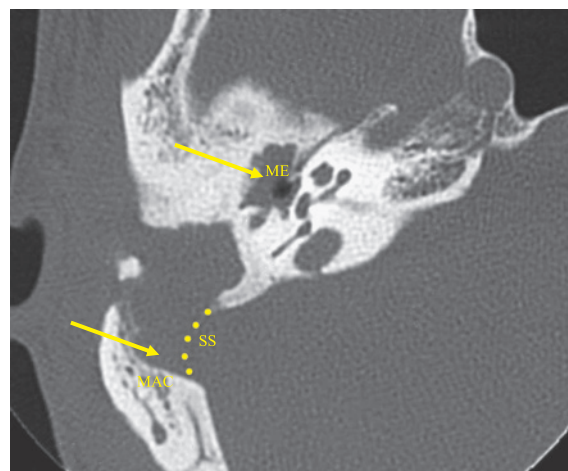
CT scan of base of the skull. Abbreviation. ME, middle ear. MAC, mastoid air cells. SS, sigmoid sinus.
